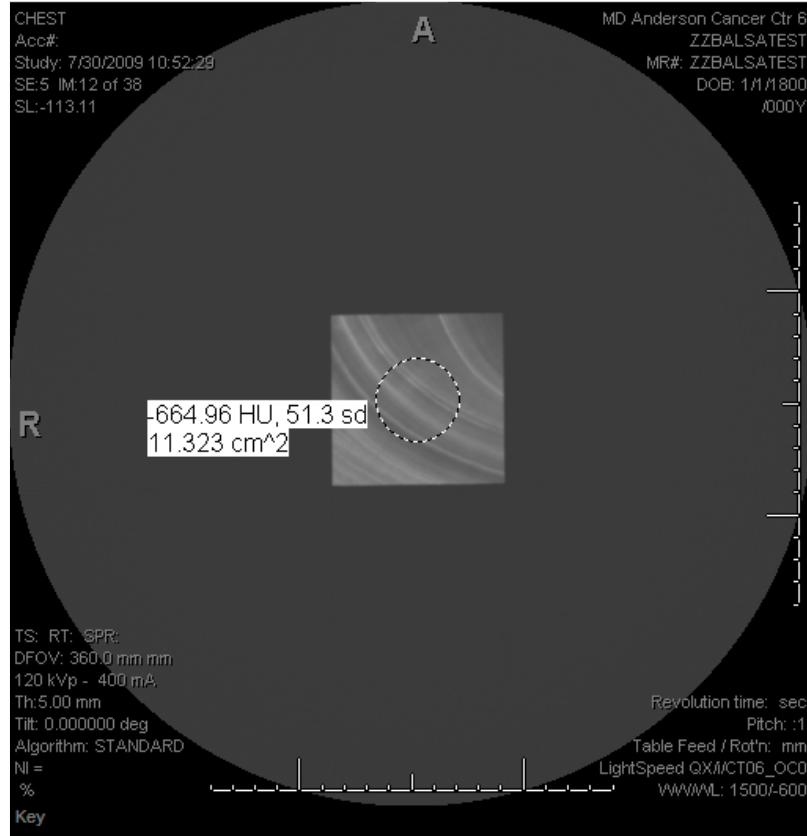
CT Image of balsa block suspended in air
